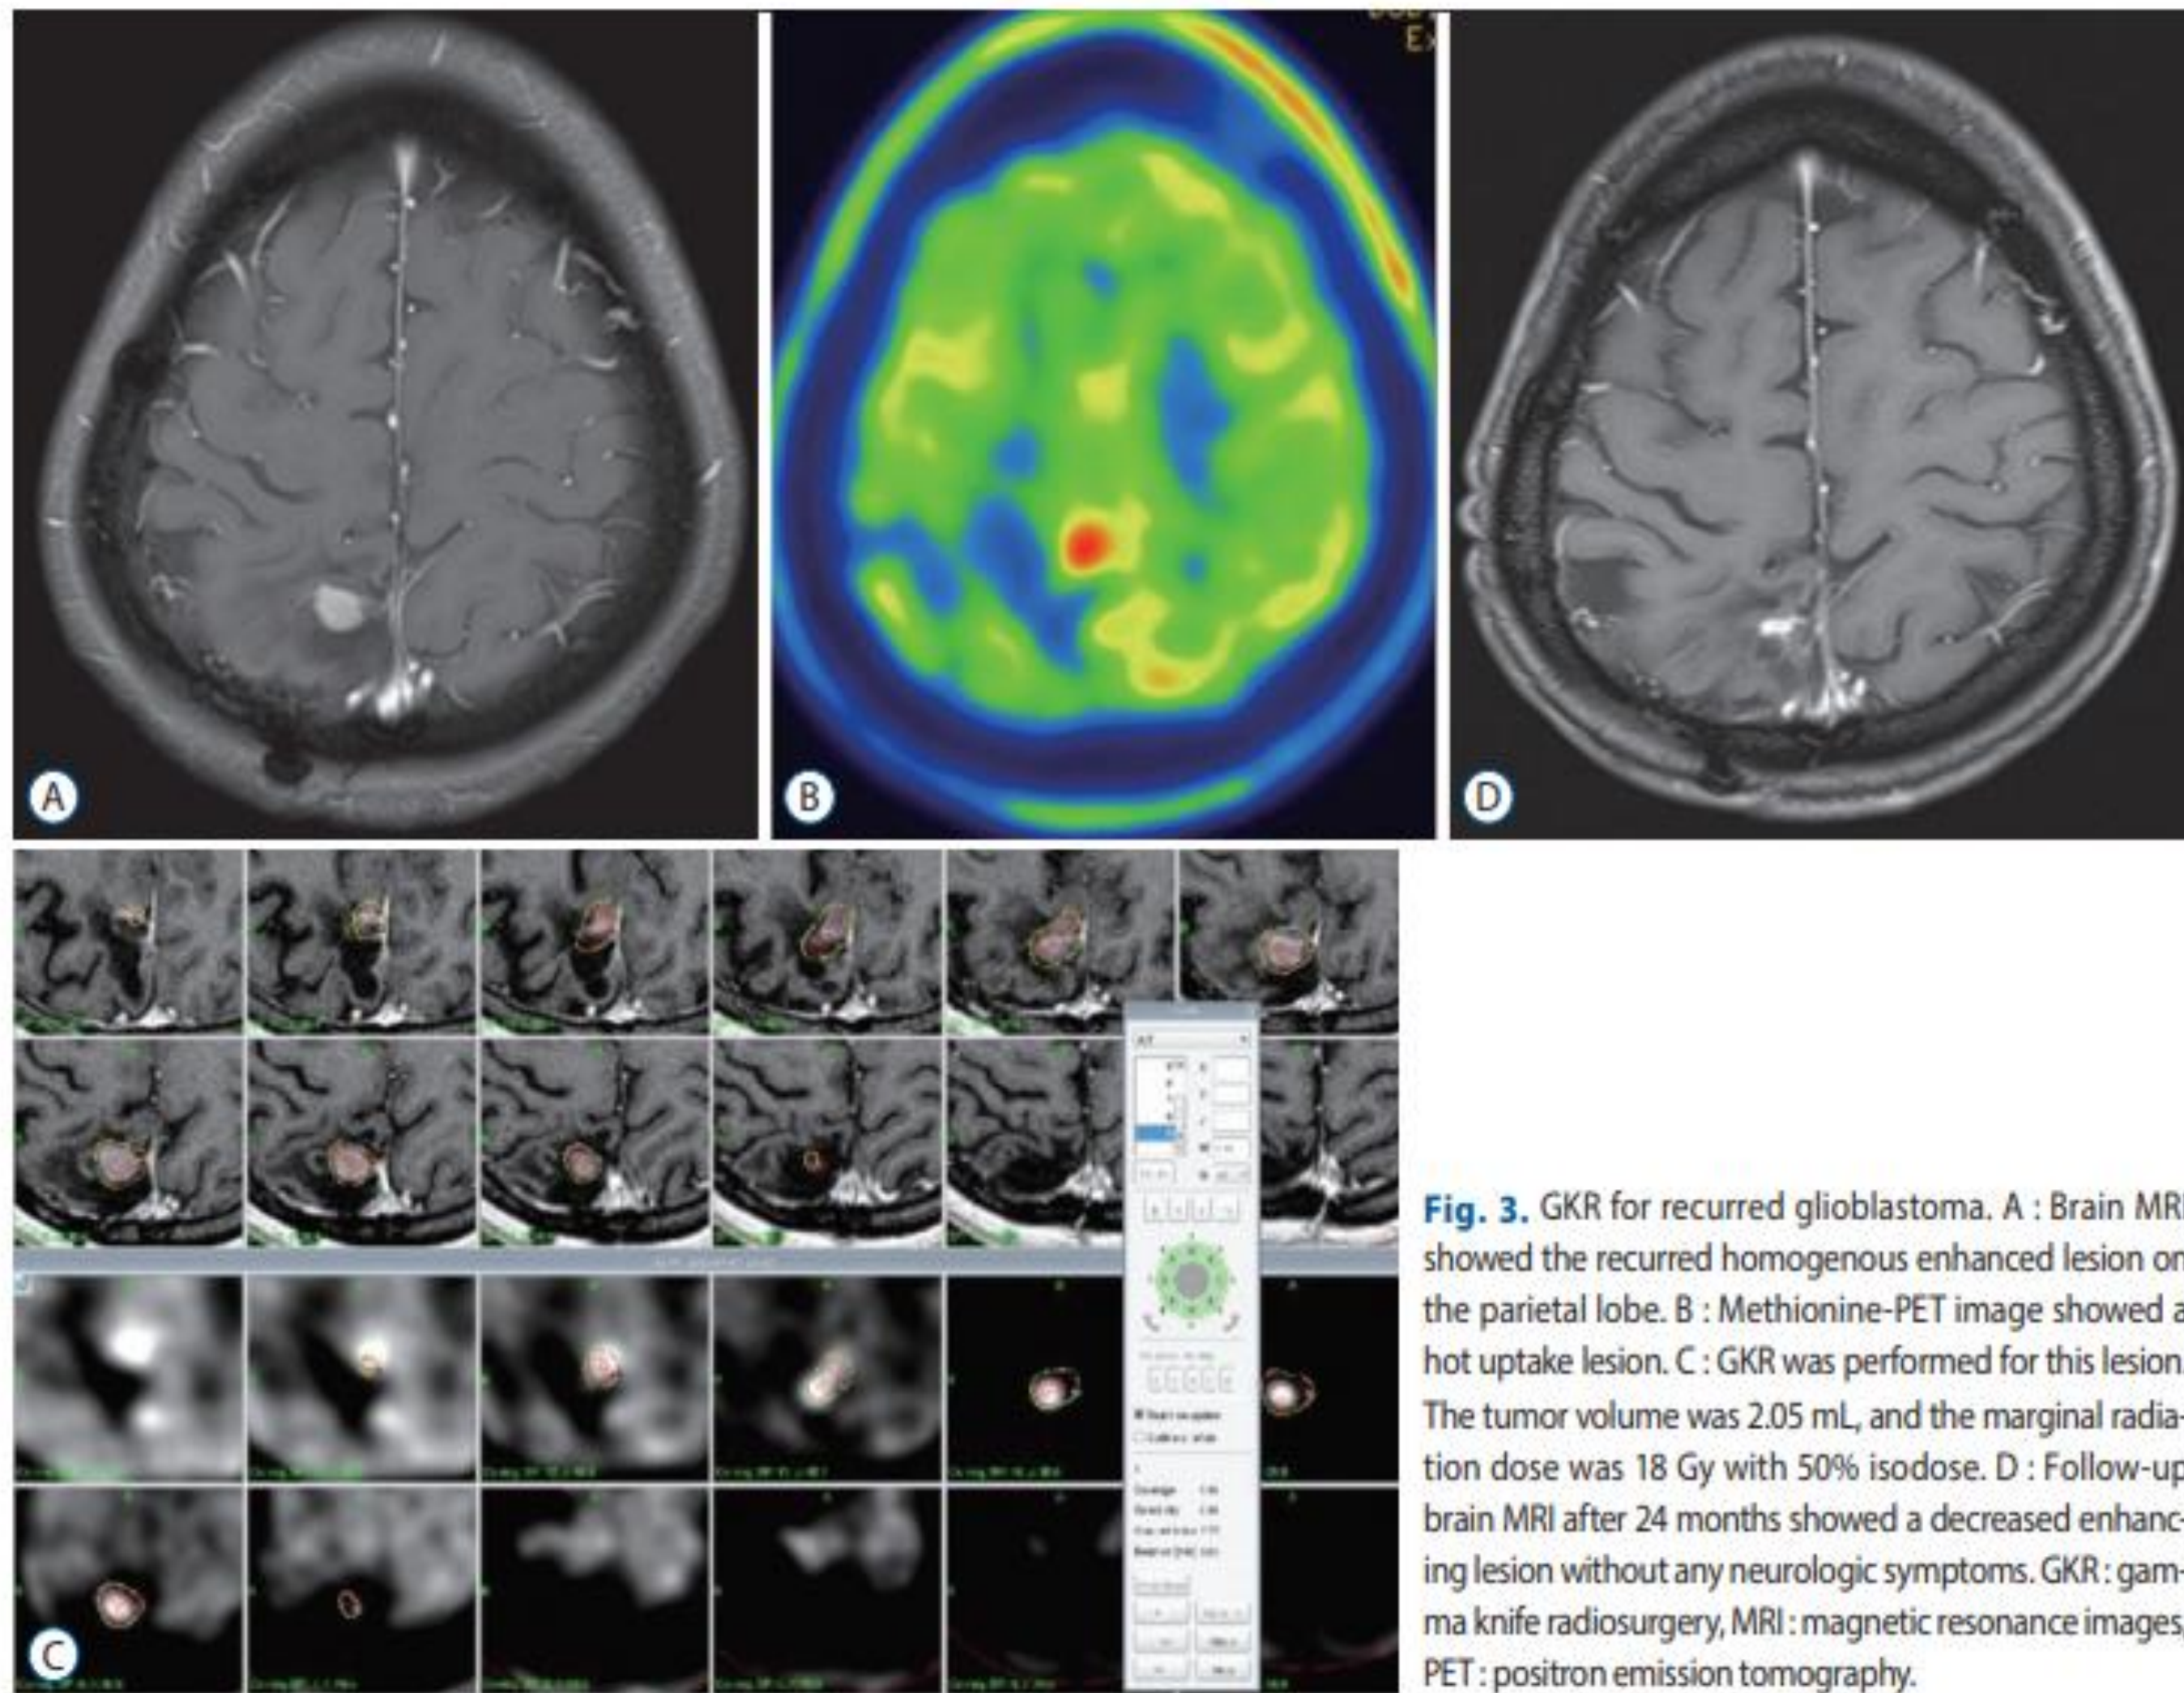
GKR for recurred glioblastoma. A : Brain MRI showed the recurred homogenous enhanced lesion on the parietal lobe. B : Methionine-PET image showed a hot uptake lesion. C : GKR was performed for this lesion. The tumor volume was 2.05 mL, and the marginal radiation dose was 18 Gy with 50% isodose. D : Follow-up brain MRI after 24 months showed a decreased enhancing lesion without any neurologic symptoms. GKR: gamma knife radiosurgery, MRI : magnetic resonance images, PET : positron emission tomography.
